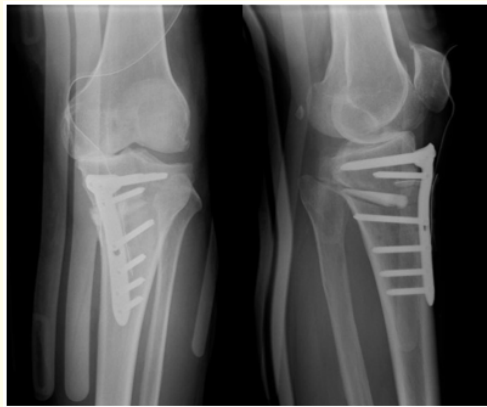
X-ray image after debridement of the abscess and poor granulation tissue. vancomycin-containing bone cement was placed adjacent to the plate and in the gap.
